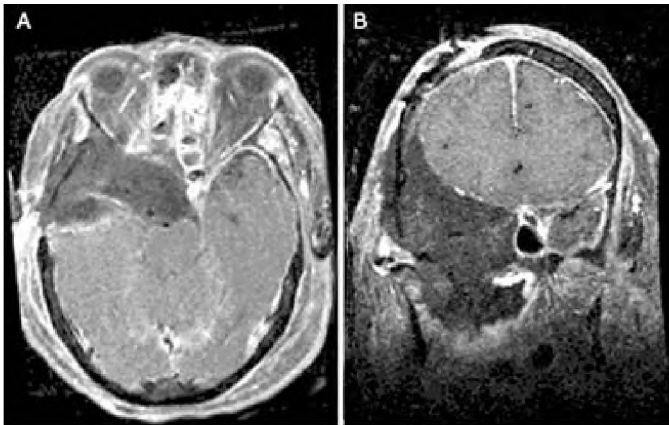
Postoperative axial (A) and coronal (B) magnetic resonance imaging showing extensive resection with a radial forearm free flap used to reconstruct cranial base. The involved segment of the internal carotid was removed with neanastomosis after resection.
